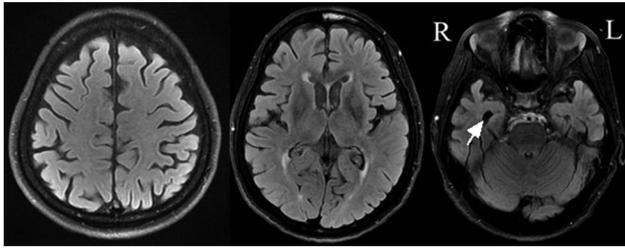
Neuroimaging of the patient. The MRI of the brain revealed right temporal lobe atrophy (white arrow) while bilateral frontal lobes and left temporal lobe were relatively less affected. R: Right; L: Left.
